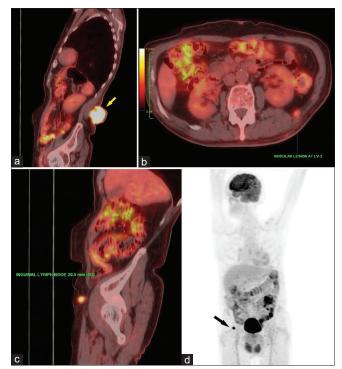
(a) FDG avid exophytic lesion in posterior abdominal wall. (b) FDG avid nodular lesions in abdomen abutting left internal oblique muscle. (c) FDG avid subcutaneous nodular lesions in right inguinal region. (d) MIP images in coronal section showing metastatic metabolically active right inquinal lymph node
